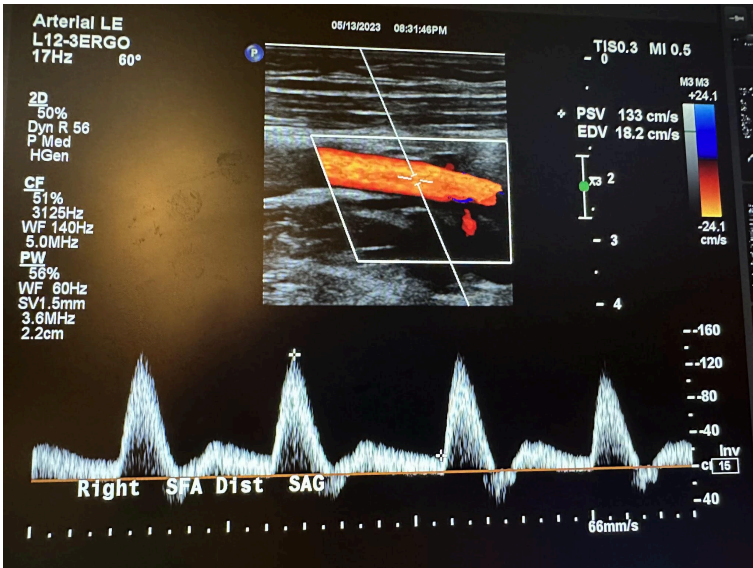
Sagittal image of the right distal superficial femoral artery with color Doppler and waveform analysis.
